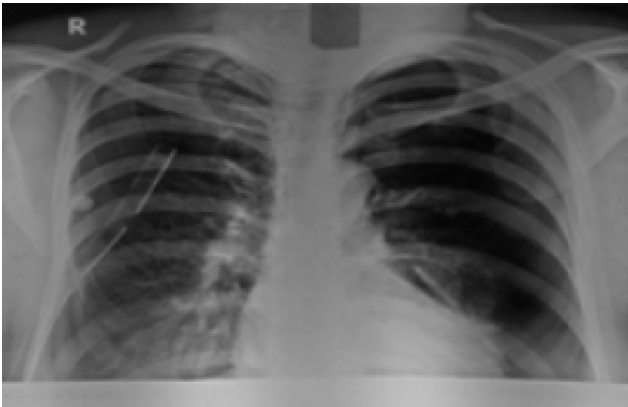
Chest radiograph (postero-anterior view) taken with abdominal shield during third episode showing left-sided pneumothorax. Intercostal tube is also evident on the right-side.
